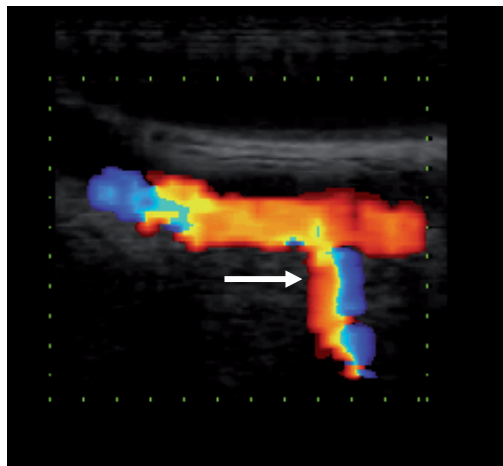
Longitudinal color-Doppler ultrasound image of the LAD with a septal perforator branch (arrow) scanned endoscopically
